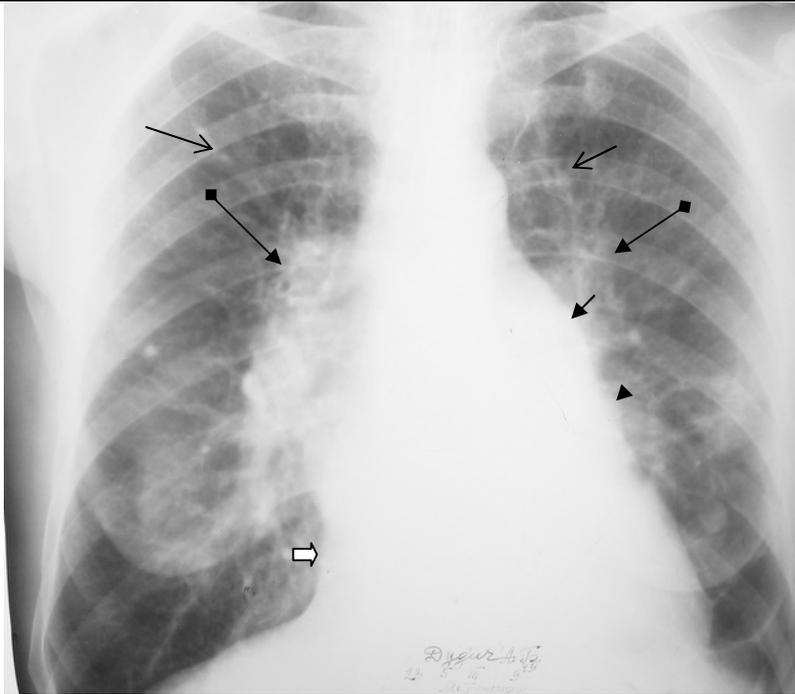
The frontal chest radiograph. Shades of roots of lungs are increased at the expense of expansion of vascular trunks forming them (an arrow with a rhombus). Lung pattern is intensified from both sides, mainly in upper departments (open arrows). The heart shadow is expanded (mitral configuration). Increase in arches on the left contour: pulmonary artery (black arrow), the left atrium (small black arrow), left ventricle (white arrow). The increased left atrium forms an additional arch on the right contour of heart (figured arrow).
